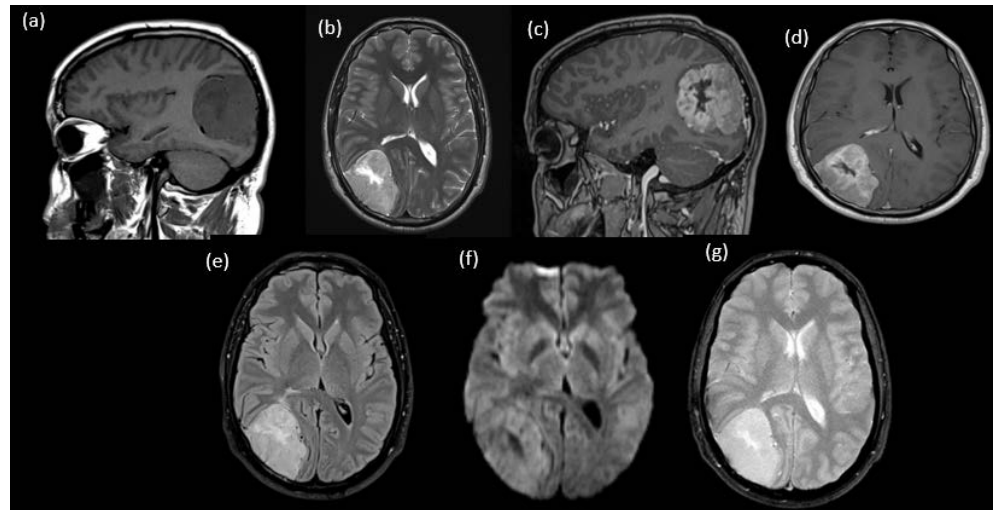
Preoperative sagittal T1-weighted (a), T2-weighted axial (b), and postcontrast T1-weighted axial (c), postcontrast sagittal T1-weighted (d), axial flair (e), axial diffusion (f), axial T2 EG(g), MR images demonstrate a right parieto-occipital extra-axial lesion that appears as hypointense on T1, hyperintense on T2, and shows heterogeneous enhancement on post-contrast T1 images and an enhancing-thickened dural tail with a small perilesional edema.
